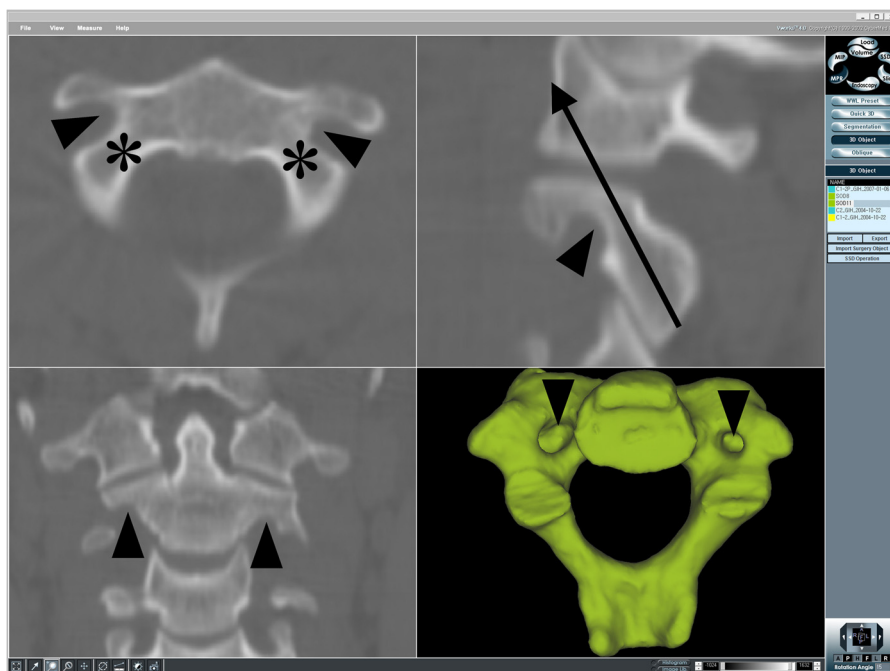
Axial, sagittal, coronal, and three-dimensional inferior computed tomography scan images of C2 show vertebral artery groove of C2 (arrowheads). It is located anteroinferior to the transarticular screw trajectory (arrow) on a sagittal plane and lateral to the pedicle (asterisks) on an axial plane.
